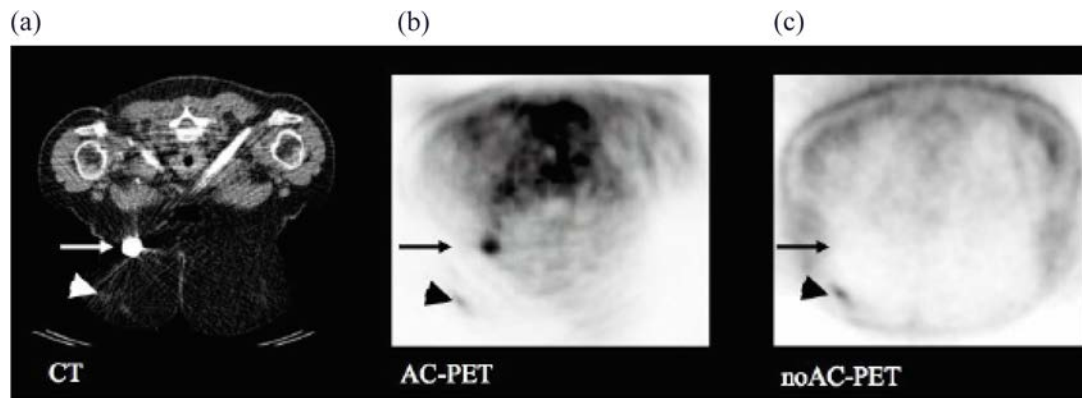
CT (a), AC-PET (b) and noAC-PET (c) of a patient with breast cancer with a chemotherapy port causing artificial tracer uptake on AC-PET. AC: attenuation corrected; noAC: not attenuation corrected.
